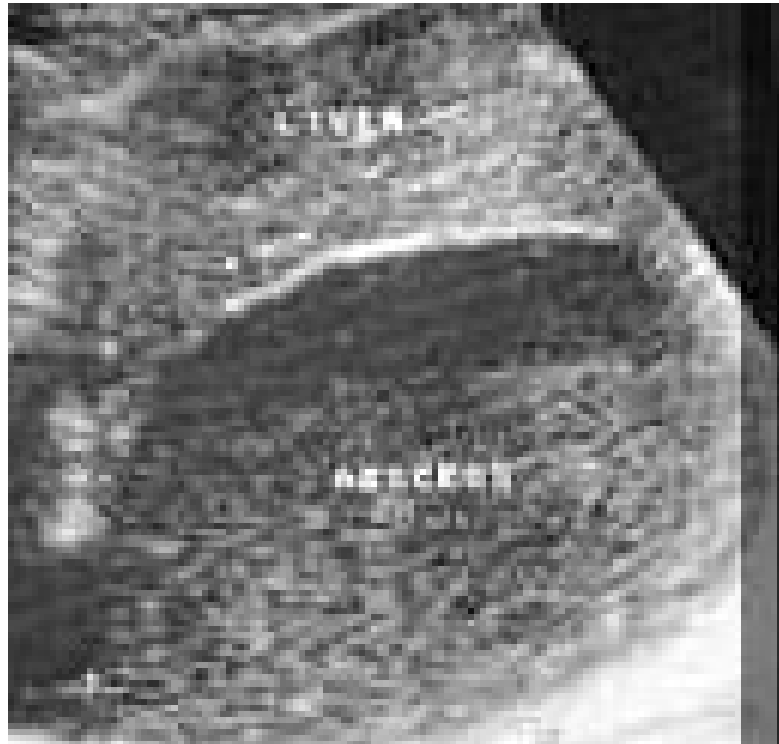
ULTRASOUND SHOWING LIVER ABSCESS
